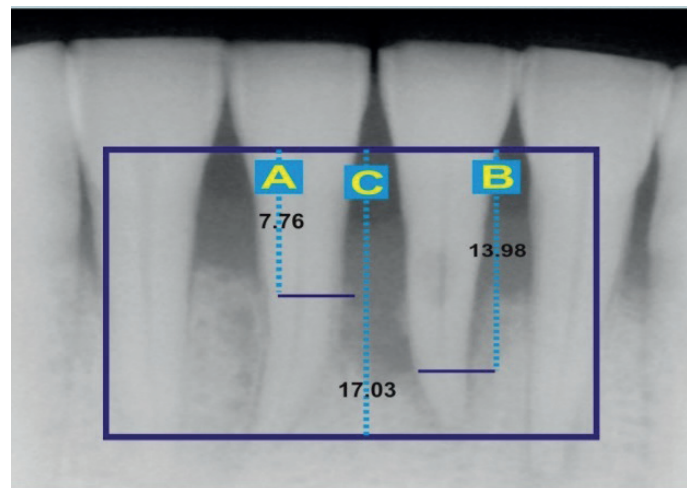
Radiographic planning of the treatment (A: cemento-enamel junction to alveolar crest, B: cemento-enamel junction to base of the defect, C: root).
